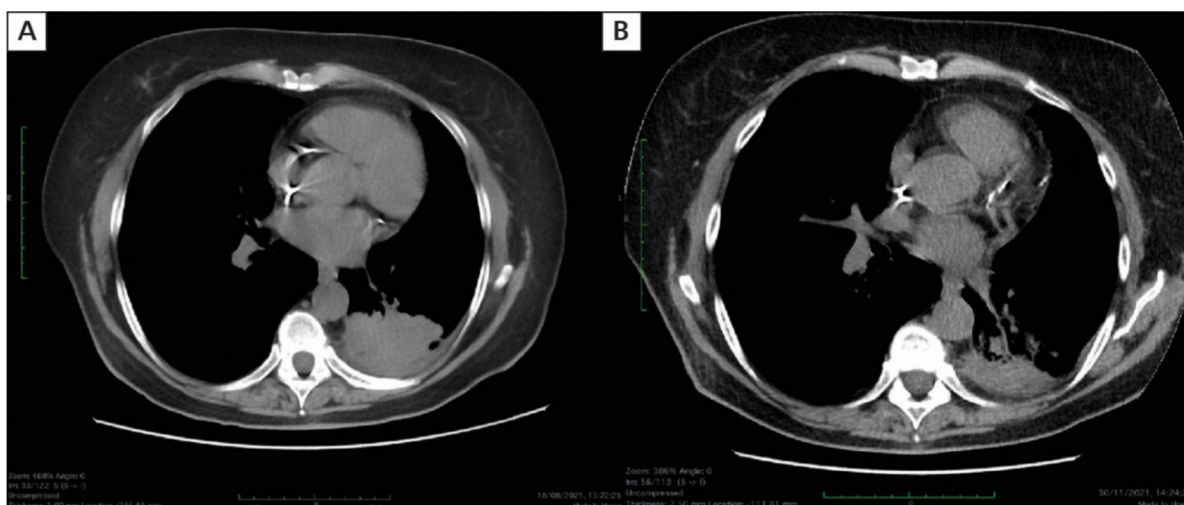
Remission of tumor in segment 6 with G12C mutation in the *KRAS* gene; A. Computed tomography (CT) performed before sotorasib therapy; B. CT performed after two months of sotorasib therapy
